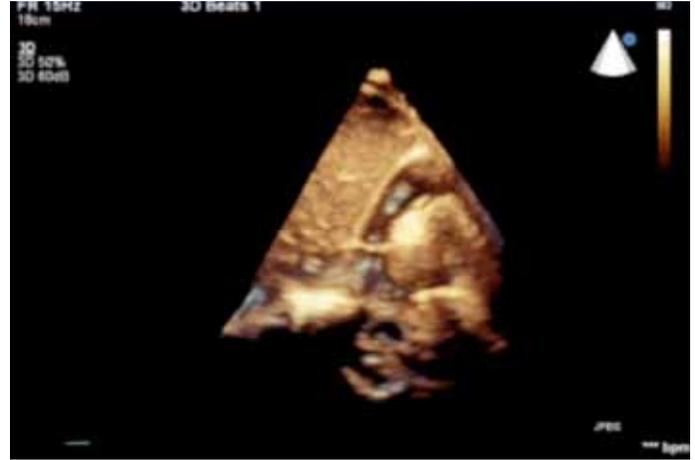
Three-dimensional echocardiography image of a point of the mass attachment at the right atrial free wall
